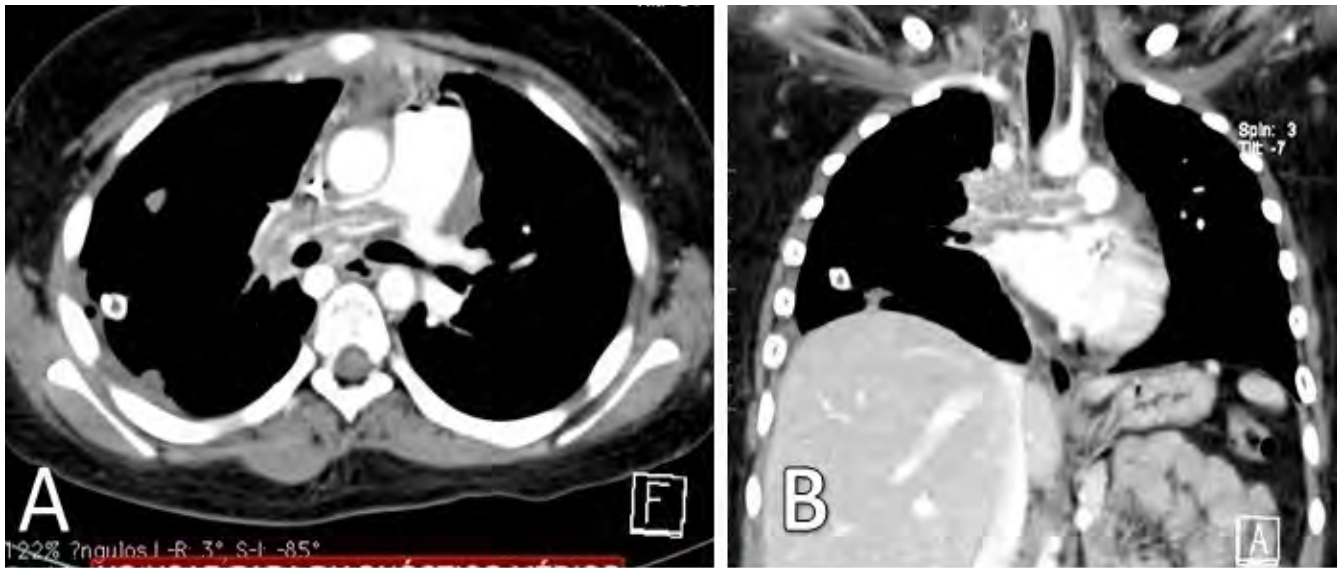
A. CT chest with contrast. A. region corresponding to the right pulmonary artery is observed with an obstruction to the contrast passage, which corresponds to the thrombosis area from the junction to the bifurcation. B. Coronal chest section. The right pulmonary artery with obstruction and no passage of the contrast medium, displaying a filling defect.
